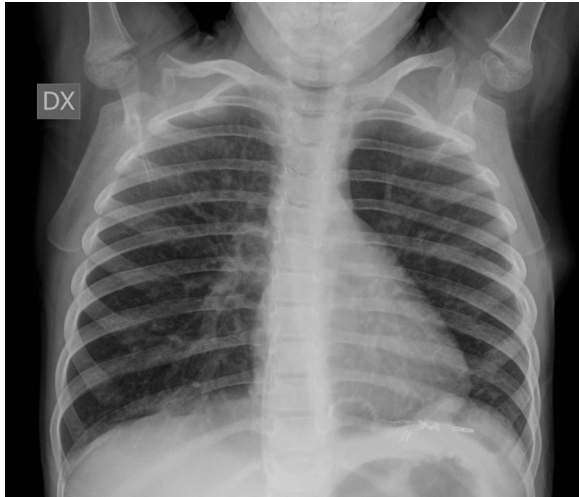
Chest X-ray 1 month after surgery.
